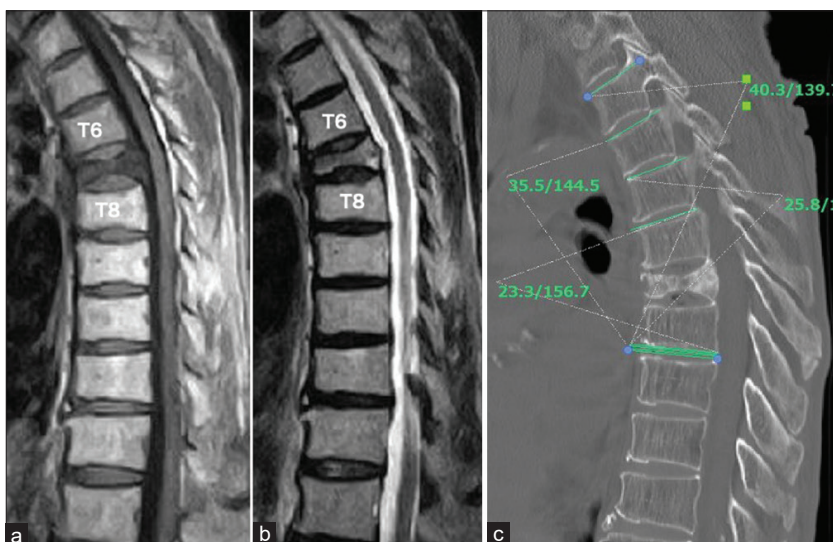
(a) Thoracic magnetic resonance imaging showed low intensity on T1WI and isointensity on T2WI at T7. (b) Thoracic kyphosis deformity was seen on thoracic spinal computed tomography after 2 months of initial onset.
